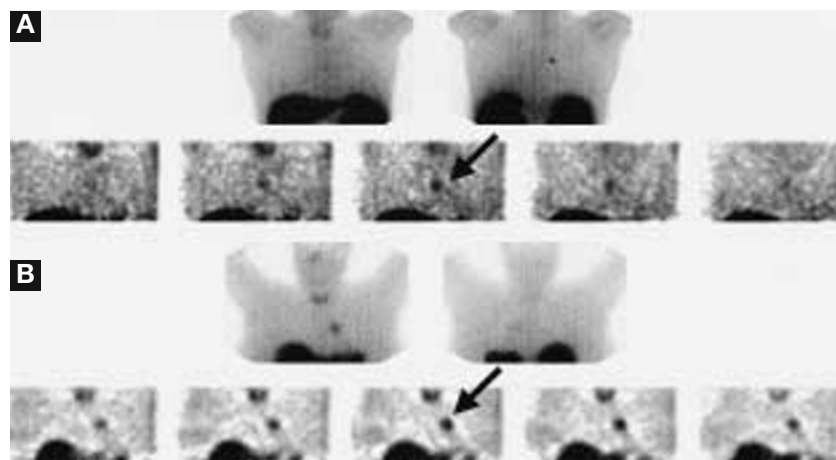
Planar (top) and coronal SPECT (bottom) images of the chest 24 h after injection of [¹¹¹In-DTPA⁰]octreotide. Planar anterior (left) and posterior (right) views. There is normal uptake in the thyroid and liver. An abnormal uptake in the region of the left hilum is seen (arrows). A) patient with A thymoma; B) patient with B2 thymoma.
